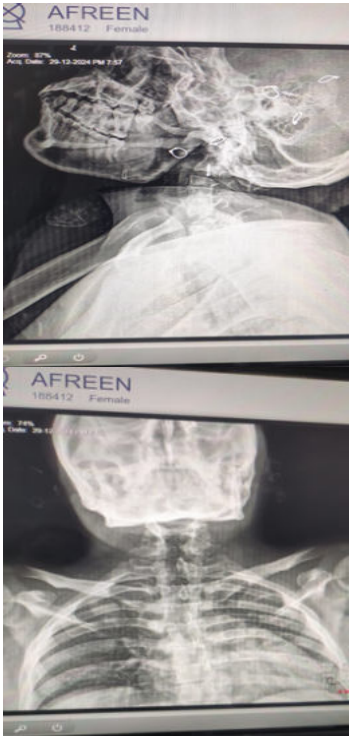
xray head and neck showing fused vertebrae
